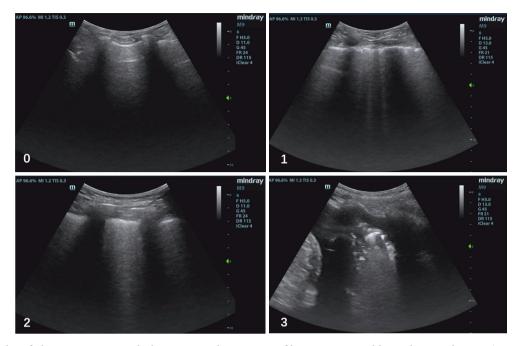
Examples of ultrasonic images with the corresponding pattern of lung aeration and lung ultrasound score (0, 1, 2, and 3 points). AP, acoustical power; MI, mechanical index; TIS, thermal index of soft tissue; m, marker; B, B-mode; F H 5.0, harmonic wave with a frequency of 5 MHz; D, penetration depth (cm); G, gain; FR, frame rate (frames per second); DR, dynamic range; iClear, Mindray's unique image enhancement feature, where 4 represents the 4th gear.
